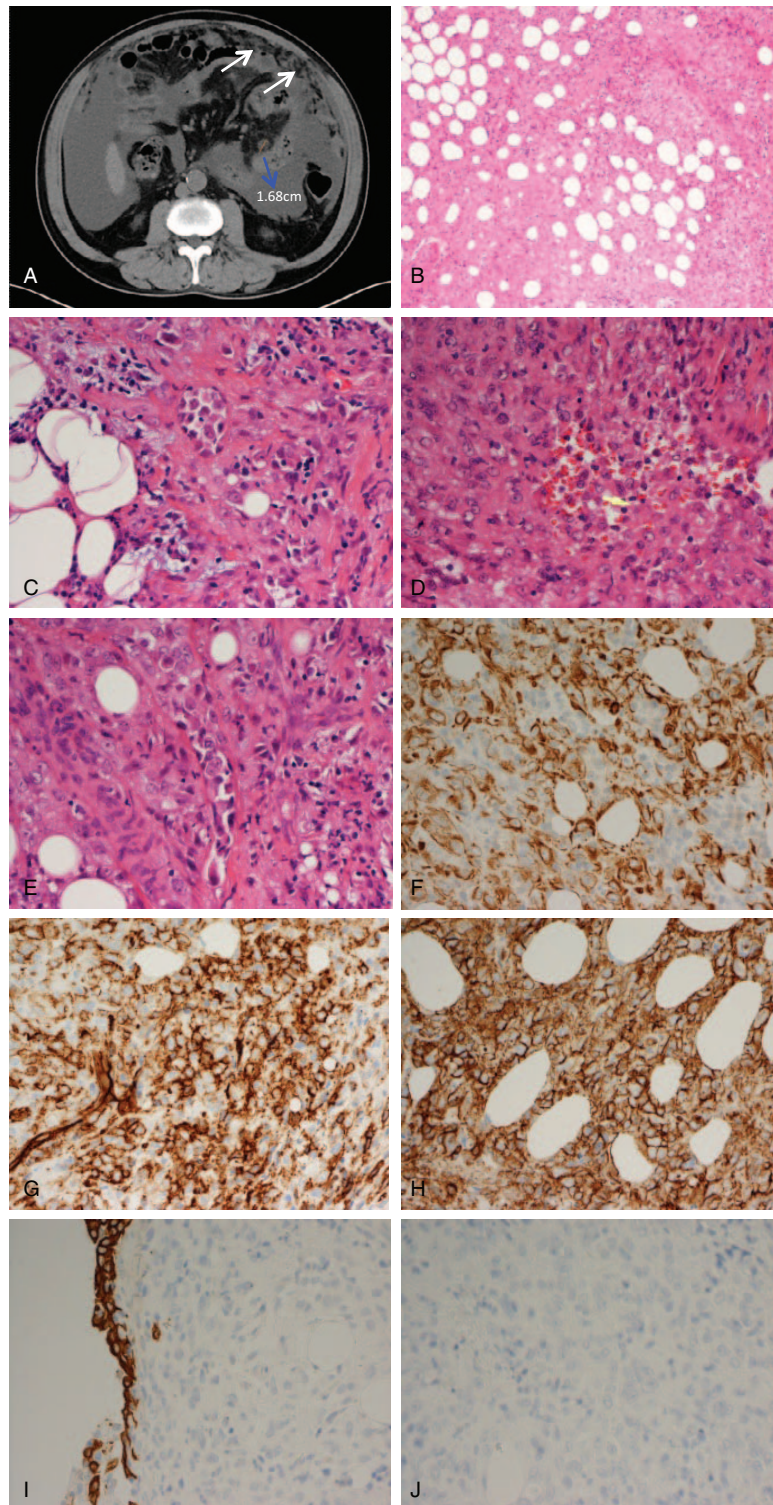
(A) Computed tomography scan of the abdomen demonstrated peritoneal carcinomatosis thickening (white arrows) and fluid accumulation in the abdomen. The largest tumor was about 1.68 cm (blue arrow) (B) 100 ×, (C) 400 ×, (D) 400 ×, (E) 400 ×, (F) CK(+), (G) CD31(+), (H) CD34(+), (I) CK7(−), (J) CK20(−).
